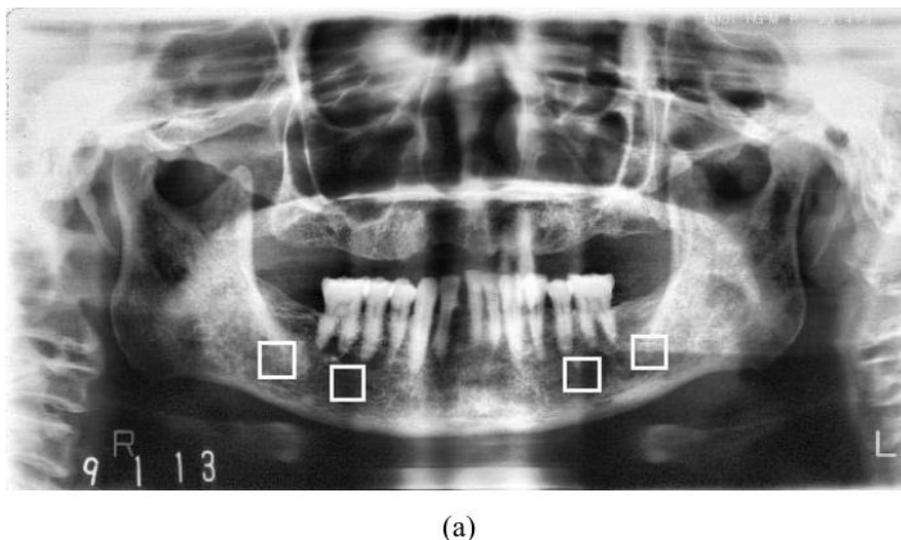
Input image. a) Four samples from a dental panoramic radiographs, b) and c) Two left hand side samples, d) and e) Two right hand side samples.
